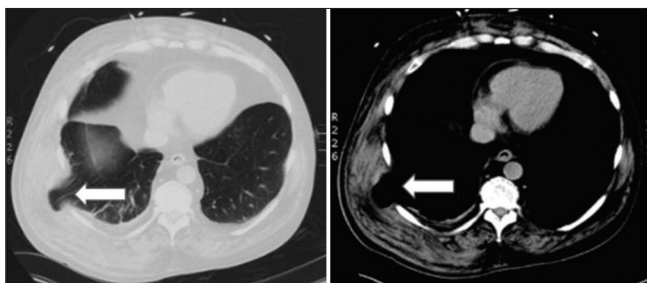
Noncontrast computed tomography of the chest demonstrating lung herniation through the intercostal space, with noted chest wall swelling due to bleeding within the muscle
